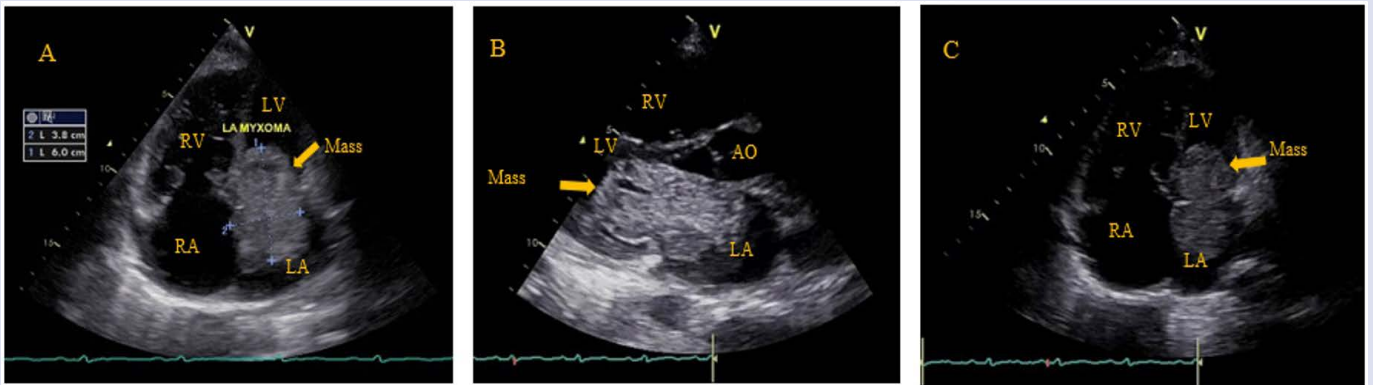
Transthoracic echocardiography (A) apical four chamber view reveals a 3.8 x 6 cm mass which its base is attached to the interatrial septum in the left atrium; (B) Parasternal long axis view showing the mass in the left atrium protruding into the left ventricle through the mitral valve during the diastolic phase; (C) Apical four chamber view shows the mass in the left atrium protruding into the left ventricle through the mitral valve during the diastolic phase.
